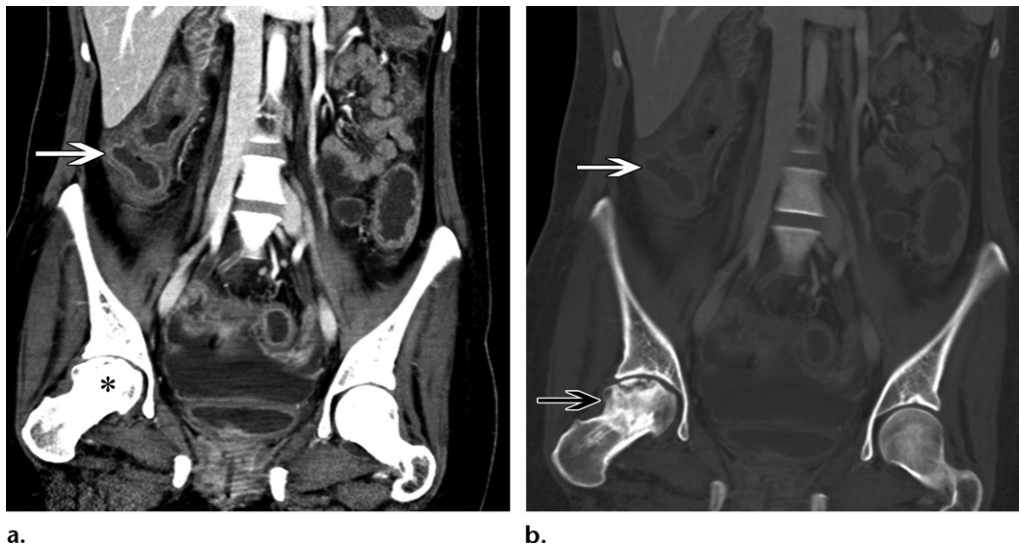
Femoral head avascular necrosis and pancolitis in a 29-year-old woman with ulcerative colitis. (a) Coronal contrast-enhanced CT image shows colonic wall thickening and mucosal hyperenhancement (white arrow), findings consistent with pancolitis. Irregularity and flattening of the right femoral head (*) is better evaluated with use of bone windows. (b) Coronal CT image (bone window) better shows the sclerosis and deformity of the right femoral head, including a subchondral fracture with femoral head flattening (black arrow), findings consistent with osteonecrosis secondary to corticosteroid therapy. Colonic wall thickening is also depicted (white arrow).
